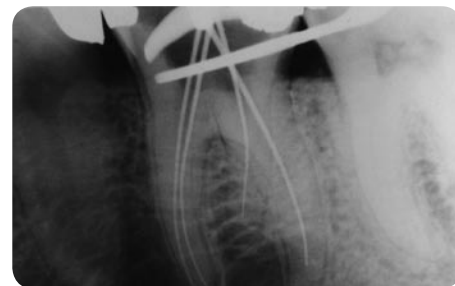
Instrument placement in a mandibular first molar. Because of the radiographic angulation, the third root appears very short. The third root curves back toward the buccal.
